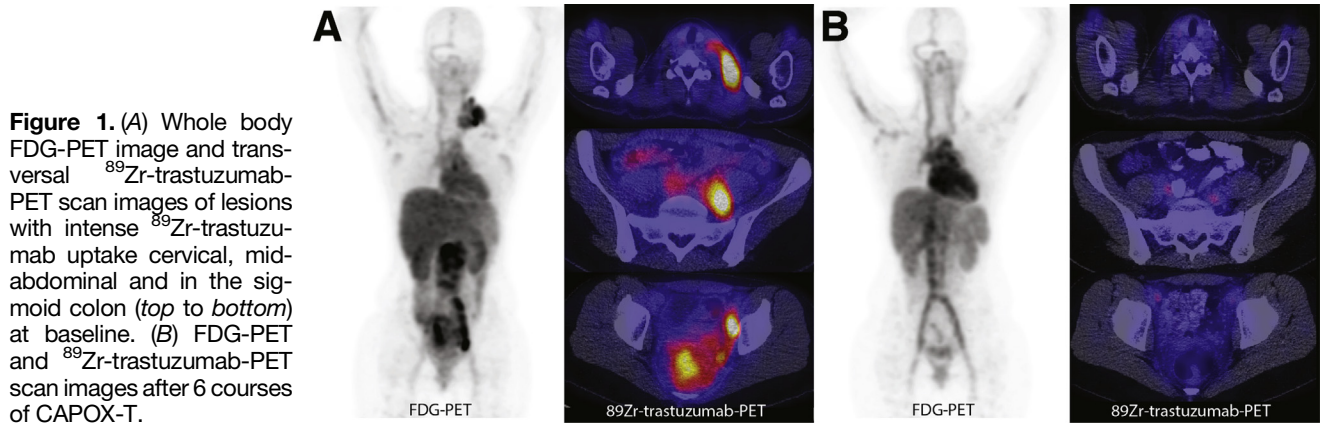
(A) Whole body FDG-PET image and transverse ^{89}Zr -trastuzumab-PET scan images of lesions with intense ^{89}Zr -trastuzumab uptake cervical, mid-abdominal and in the sigmoid colon (top to bottom) at baseline. (B) FDG-PET and ^{89}Zr -trastuzumab-PET scan images after 6 courses of CAPOX-T.
